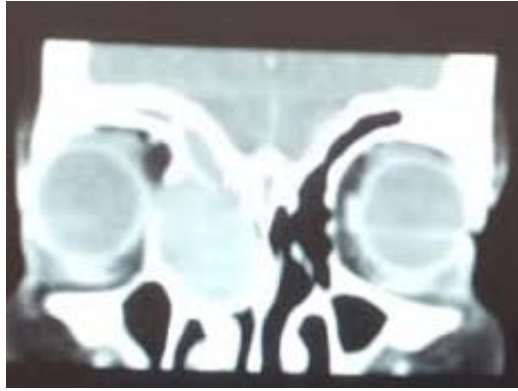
Coronal CT scan showing a right frontoethmoidal mucocele.
